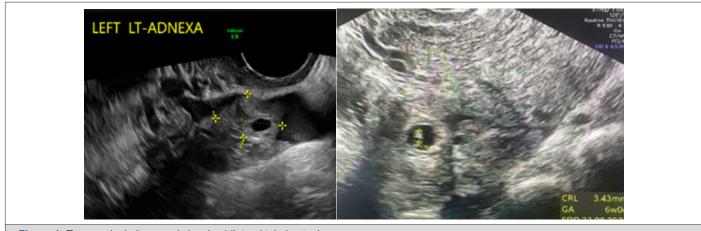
Transvaginal ultrasound showing bilateral tubal ectopic pregnancy.
